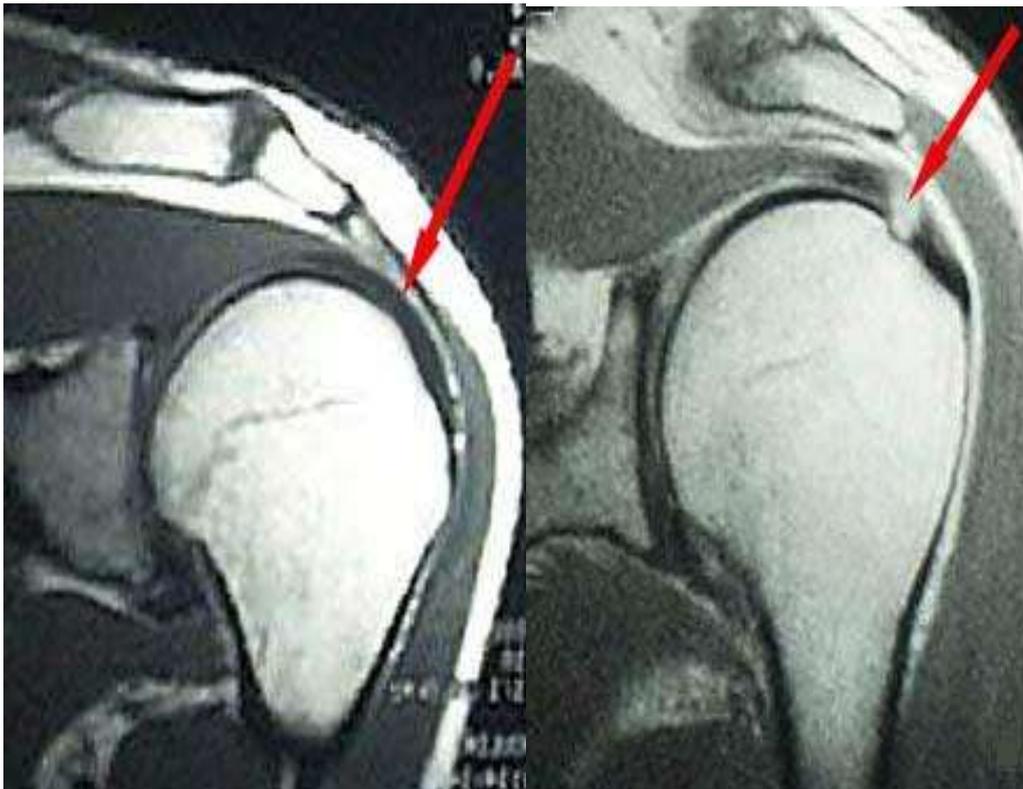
MRI Images showing rotator cuff tears and normal scans The radiographic differences between a normal rotator cuff (left) and a torn rotator cuff (right) are shown in the figures. A tear in the rotator cuff fibers is shown by the white signal that interrupts the black band on the right, in contrast to the image of a normal rotator cuff, which shows a totally black signal band below the tip of the red arrow.
